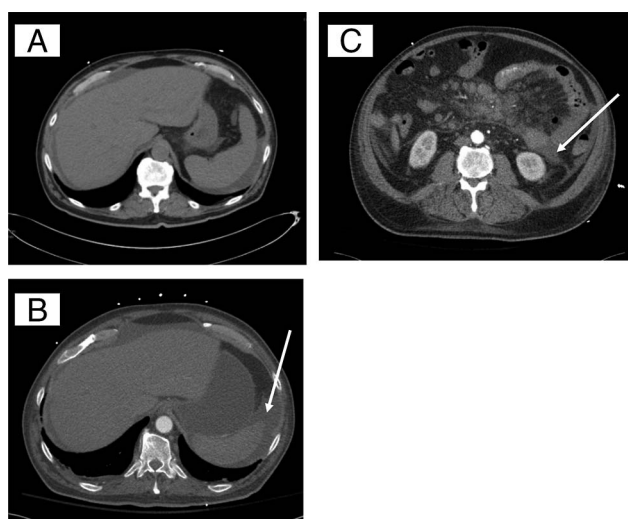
Computed tomography of abdomen and pelvis showing active gastric (A, B) and jejunal (C) extravasation.
